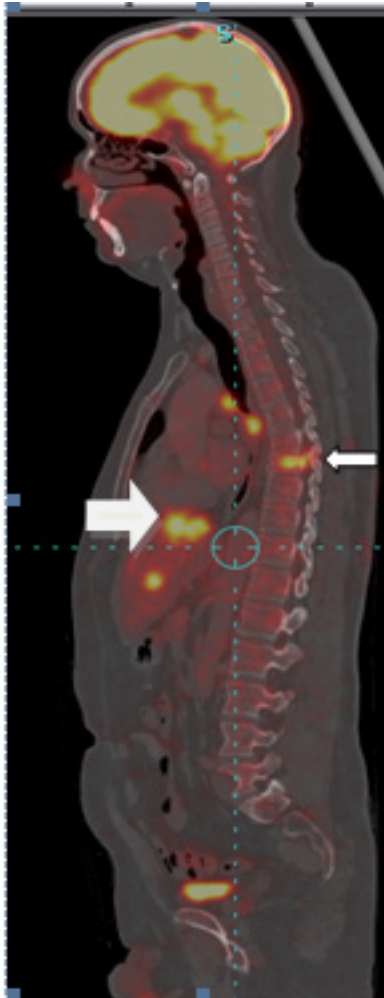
FDG PET-CT Scan of the patient showing FDG avid paraspinal mass (thin arrow) and multiple liver metastases (thick arrow).
